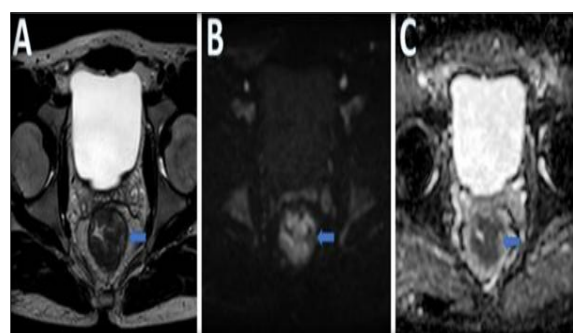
T2W MR axial image. B. DWI. C. ADC image of a 35-year-old man with pathologically proven moderately differentiated adenocarcinoma of the mid- and lower rectum (T3N1M0) showing circumferential tumor with diffusion restriction (blue arrows)
